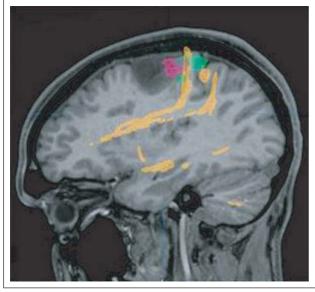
Fusion of [F-18]fluoroethyltyrosine: PET (red), functional MRI (green), and DTI tractography (yellow) in a patient with a left frontal anaplastic astrocytoma. Note the close vicinity of eloquent cortical and subcortical structures to the tumour borders
